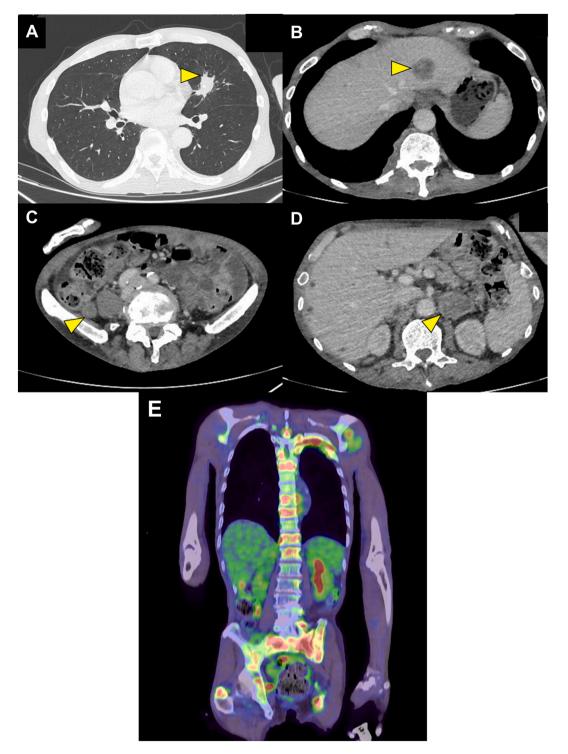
Computed tomography (CT) and positron emission tomography (PET)-CT findings 9 months after diagnosis. A) The lung nodule size was 25 mm, and no significant enlargement was observed compared to that before the treatment (arrowhead). B) Hypoattenuating hepatic lesions were evident in segment 2 (arrowhead). C) A 21-mm-sized mass was detected in the right retroperitoneum (arrowhead). D) There was a 39-mm-sized mass in the left adrenal gland (arrowhead). E) PET-CT (coronal view) depicted multiple bone metastases in the scapula, ribs, clavicles, pelvis, and vertebrae.
